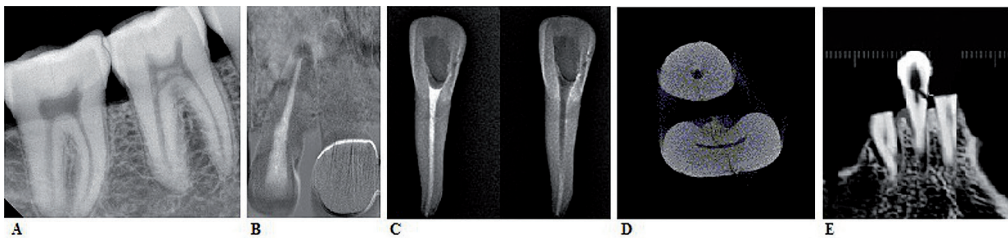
An examples of using different visualization methods of root canal systems. A: Direct Digital Radiography; B: Digital Subtraction Radiography. It reverses the shadows of gray for diagnostic purpose; C: Digital Subtraction Radiography with contrast medium; D: Microtomography; E: Cone-beam computed tomography
